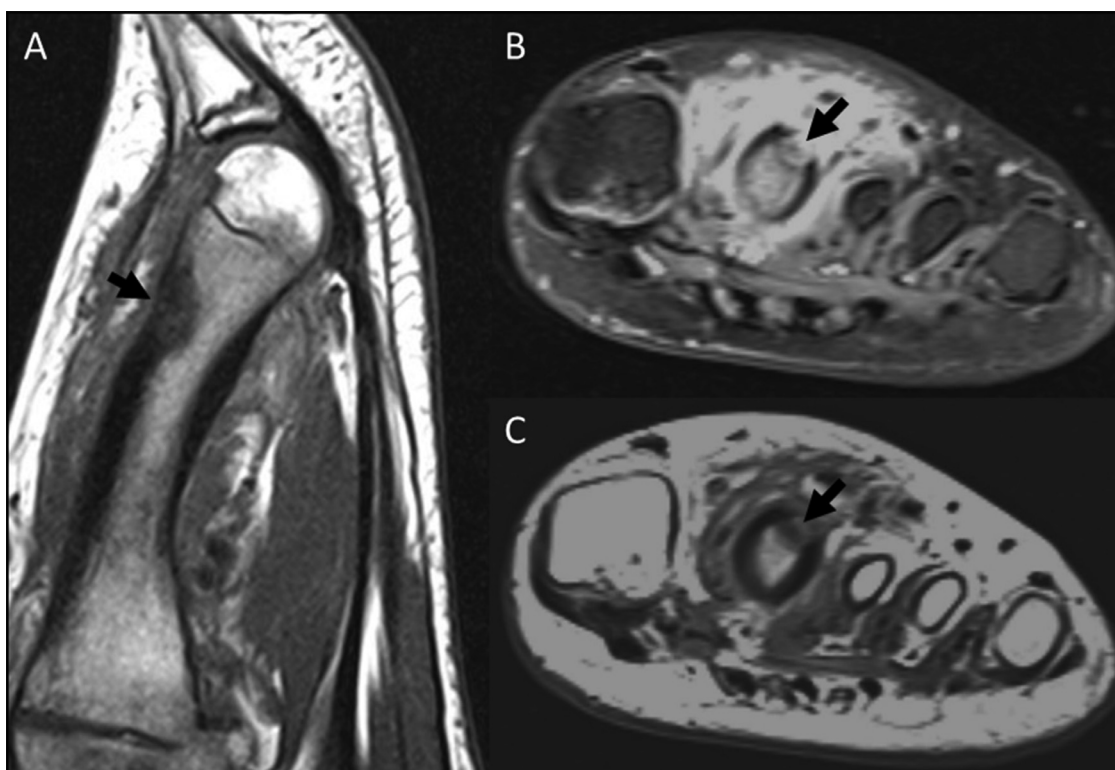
MRI of the left foot of a 14-year-old boy, sagittal T1-weighted (A), transverse proton density (B), and transverse T1-weighted (C) images demonstrating an intracortical oval-shaped lesion consisting of a central nidus and cortical thickening on the distal part of the second metatarsal bone (arrows). Edema is also evident in the adjacent bone marrow and nearby soft tissues
